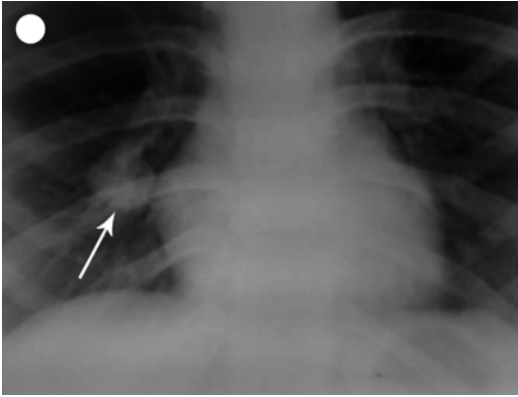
Chest X-ray showing secondary in the lung
